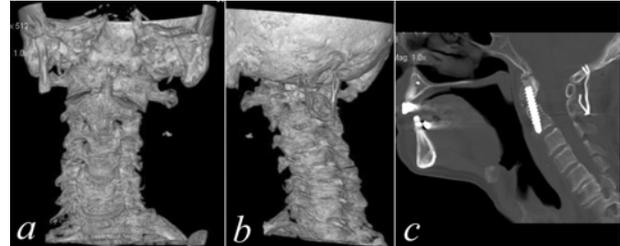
Type II dens fracture non-union managed with modified posterior occipitocervical fusion followed by direct odontoid screw fixation. a, b – CT 3-D reconstruction; c – fine-cut helical CT
